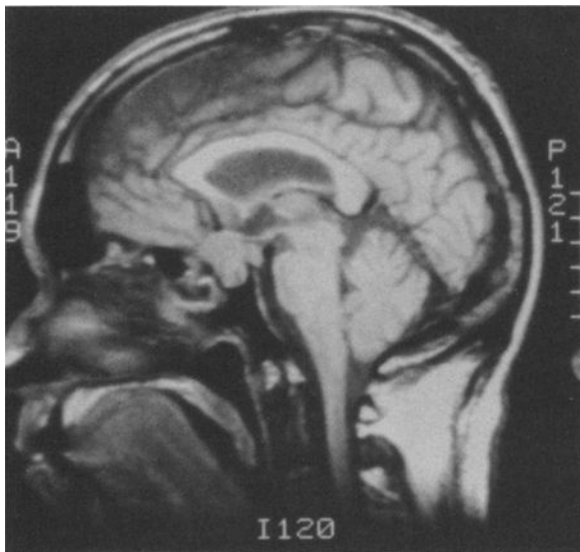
Preoperative magnetic resonance image demonstrating a large sellar mass with suprasellar extension.
